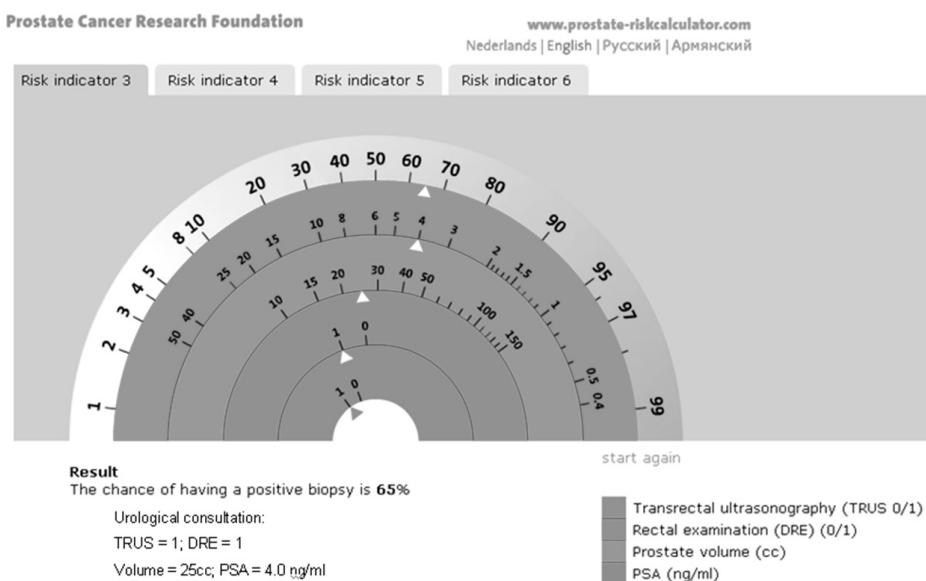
Riskcalculator step 3. Prediction of the chance of a positive sextant biopsy in a man who was never screened before; PSA = 4.0 ng/ml, high risk. This figure shows the prediction of a positive biopsy, making use of the results of transrectal ultrasound (TRUS), digital rectal examination (DRE), prostate volume at ultrasonography and PSA-value. In this example a man with a PSA-value of 4.0 ng/ml, abnormal TRUS and DRE and prostate volume of 25cc were used, which results in a 65% chance.
